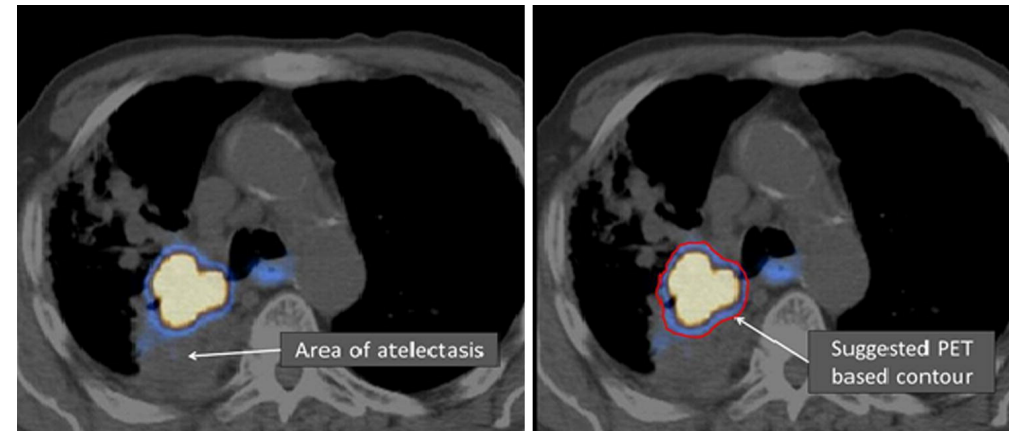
Area of atelectasis in the right upper lobe. CT images show insufficient contrast between tumor and non-tumor tissue where atelectasis is present, therefore delineation should be defined by PET FDG avid areas.
